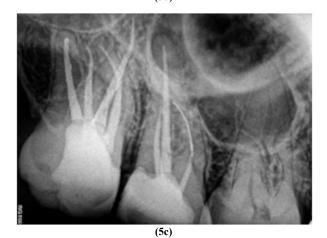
(a,b,c) Obturation Radiograph from different angulation
